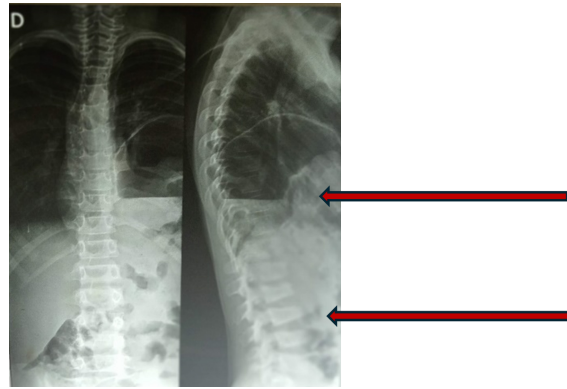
Standard radiographs of the thoracolumbar spine: The first arrow points a ascension of the left diaphragmatic dome with hydroaeric level indicating the presence of hollow organs; The second arrow points the wedge-shaped vertebrae L2, L3, L4.
